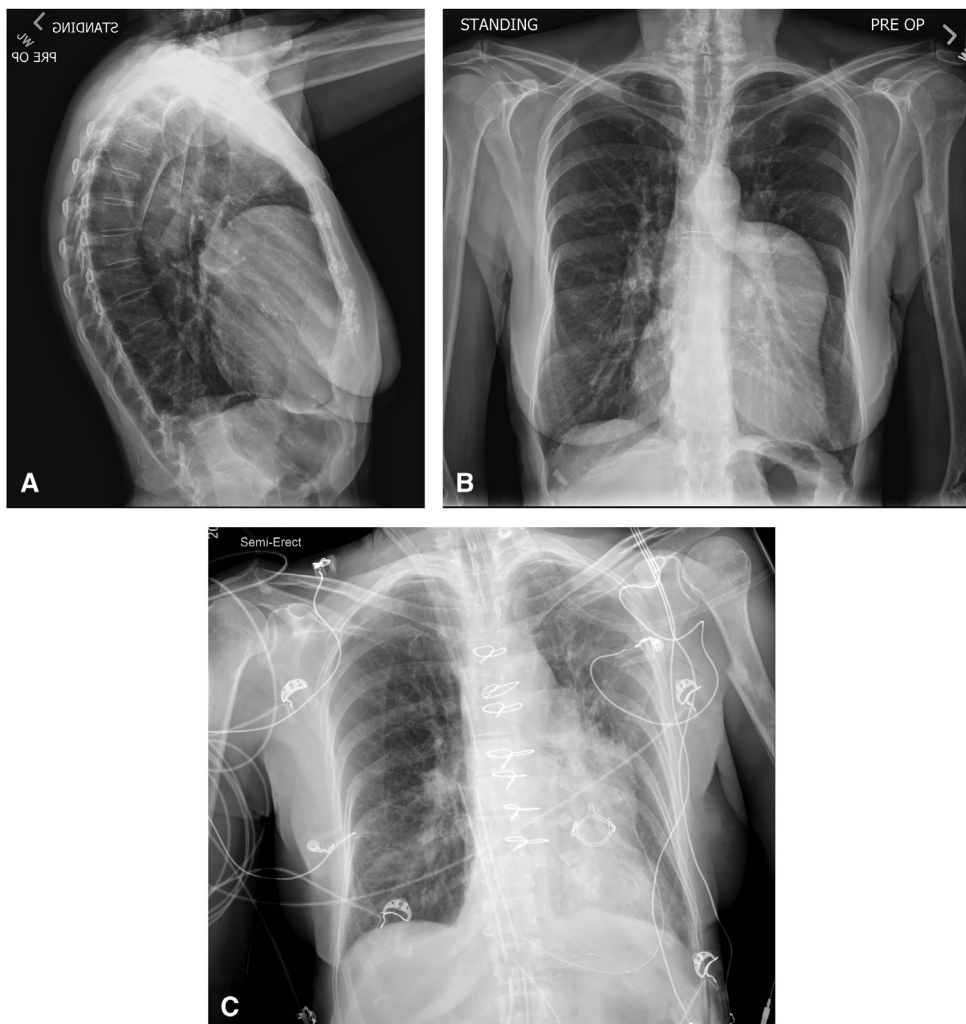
Preoperative lateral (A) and posterior-anterior (B) chest radiographs demonstrating dilation of the PA. C, Postoperative posterior-anterior chest radiograph with prosthetic valve. *PRE OP*, Preoperative.
